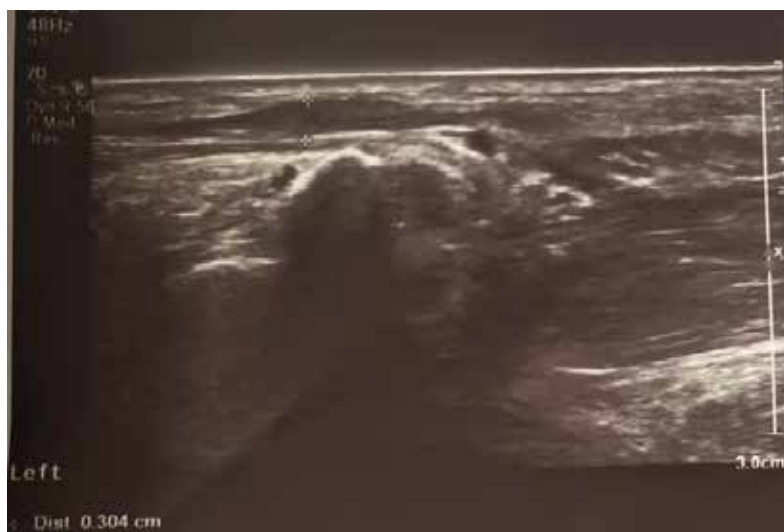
Ultrasonographic view of EPL: hypoechoic area measuring about 3 mm at the site of tendon rupture.
